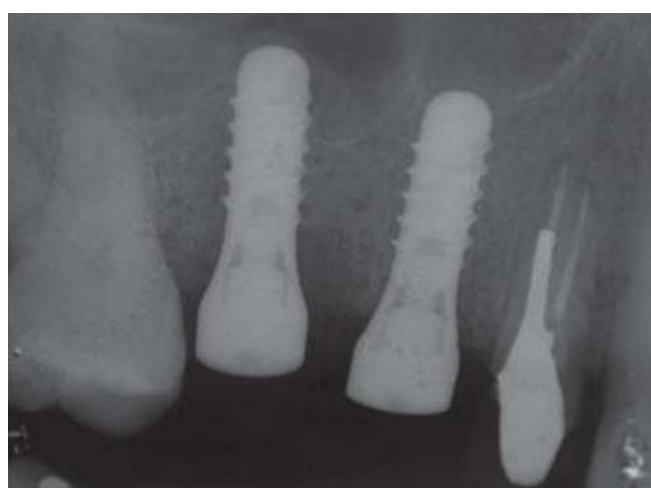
Periapical radiograph after immediate implants placement following osteotome SFE with both implants appropriately positioned and inclined
